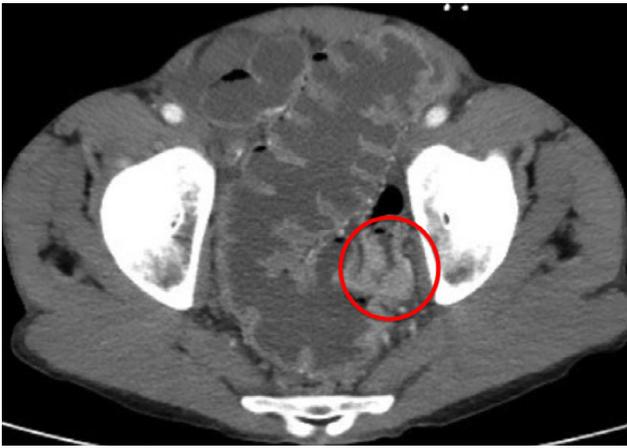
Obstructing rectosigmoid mass seen on CT.
